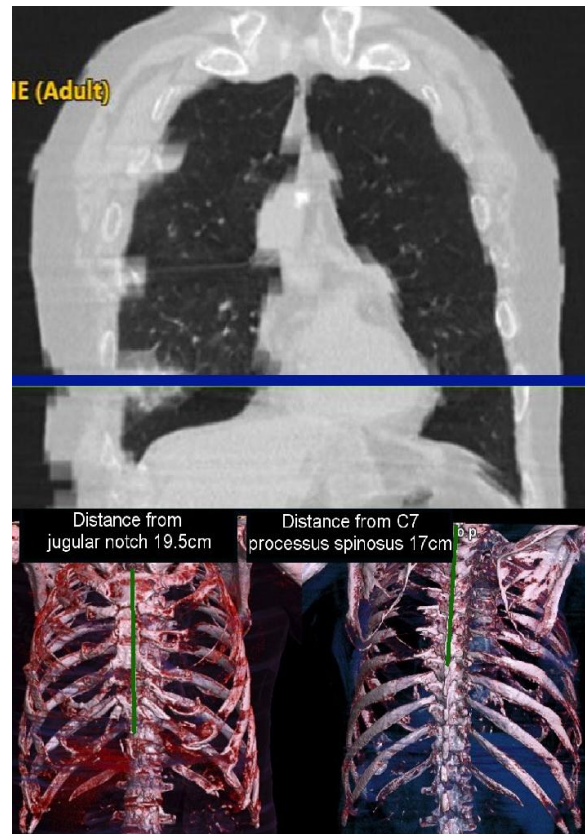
A CT scan and 3D reconstruction of the thorax of patient 2
